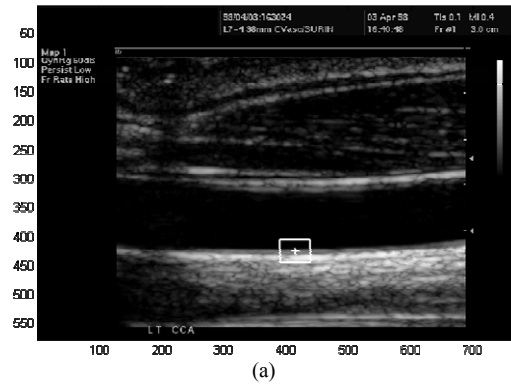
Real ultrasound image with a selected ROI on the posterior arterial wall (a) and radial (b) and (c) axial displacement and (d) correlation coefficient waveforms for this ROI estimated using the investigated block matching techniques.
